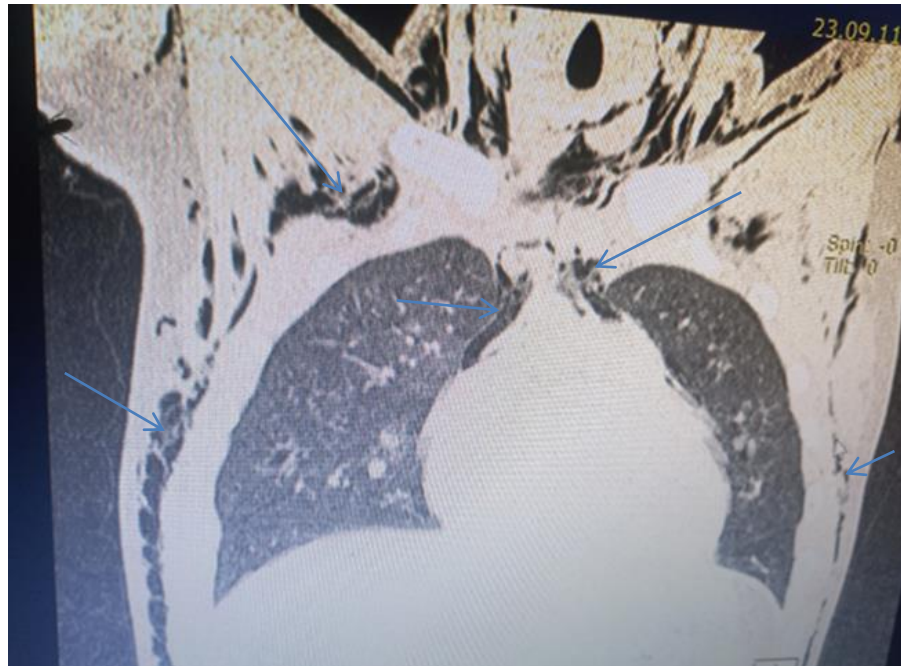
Coronal view of Chest CT scans showing pneumomediastinum and subcutaneous emphysema
